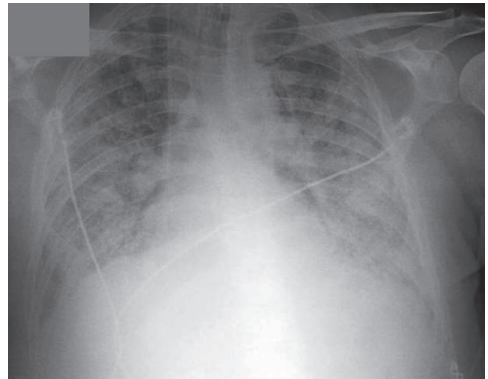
Patient 3: Chest X-ray which shows near complete involvement of lung parenchyma by patchy infiltrates. This film was obtained the day before he died.
